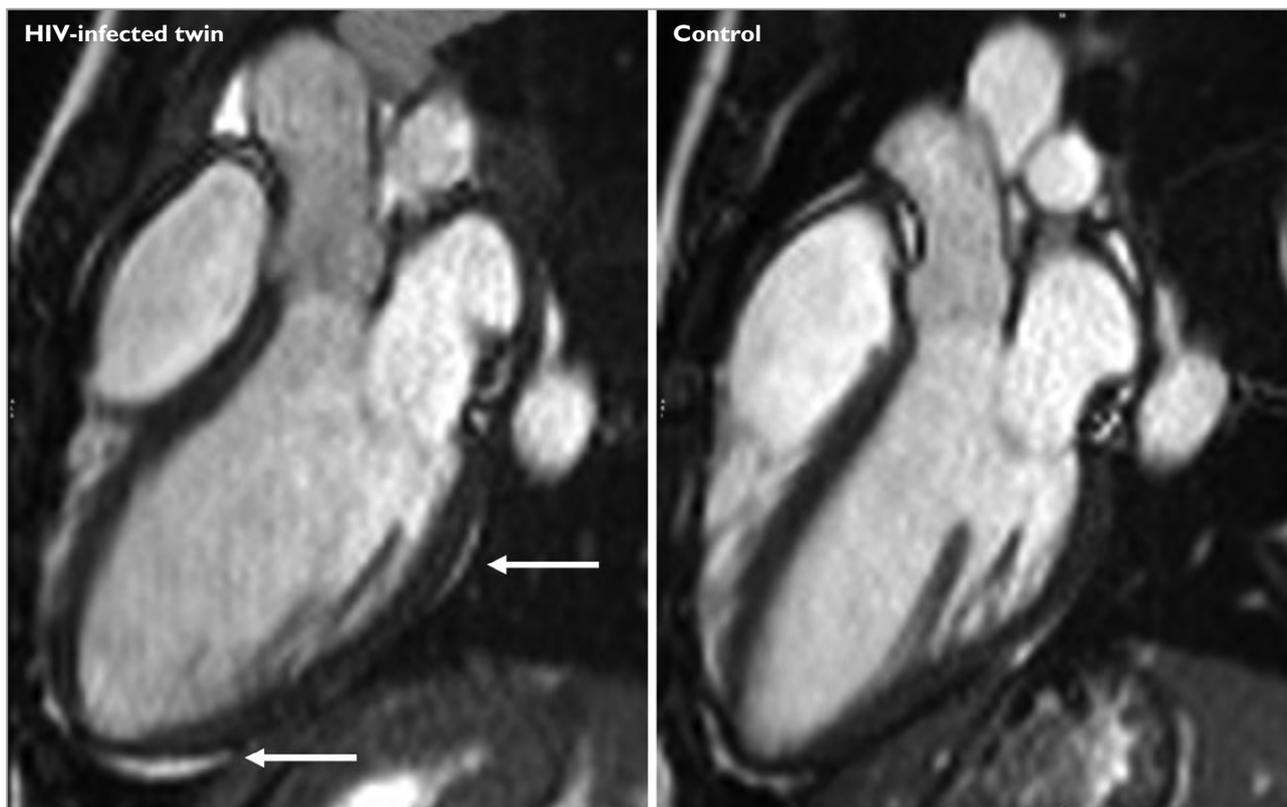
Cardiovascular magnetic resonance imaging (balanced steady state free precession image), end-diastole freeze frame of an HIV-infected female (left) and her HIV-uninfected, identical twin sister (right). The left ventricle of the HIV-infected twin appears globular and remodelled compared with her sister, with midventricular end-diastolic diameters of 50 and 47mm respectively. Note the small pericardial effusion in the HIV-infected twin (white arrows).
